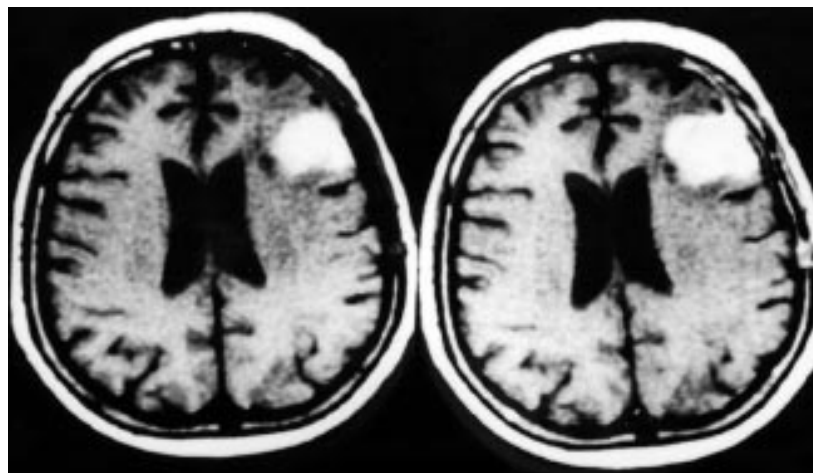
MRI of cranium showing a mass of 6x4 cm in diameter, located in the left frontotemporal lobe, showing moderate enhancement after intravenous contrast material injection.
